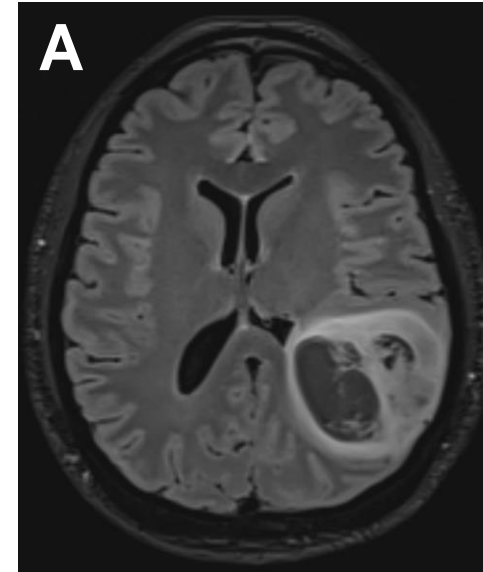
Pre-operative (A) and post-operative (B) T2 FLAIR MRI sequences demonstrating successful resection of left parietal lobe neoplasm.
